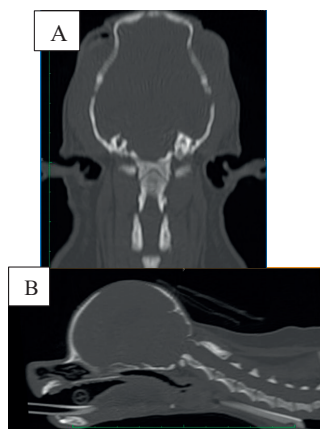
Dorsal (A) and sagittal (B) reconstructions of the cranio-cervical junction reveal hypoplastic occipital condyles, a mild dorso-ventral elongation of the foramen magnum, and a subtle misalignment of the atlas with ventral displacement. At the atlantoaxial joint, there is malposition of the vertebral lamina, characterized by significant widening of the space between the dorsal tubercle of C1 and the spinous process of C2, which spontaneously corrected with CT positioning. Additionally, a slight hypoplasia of the dens is noted
